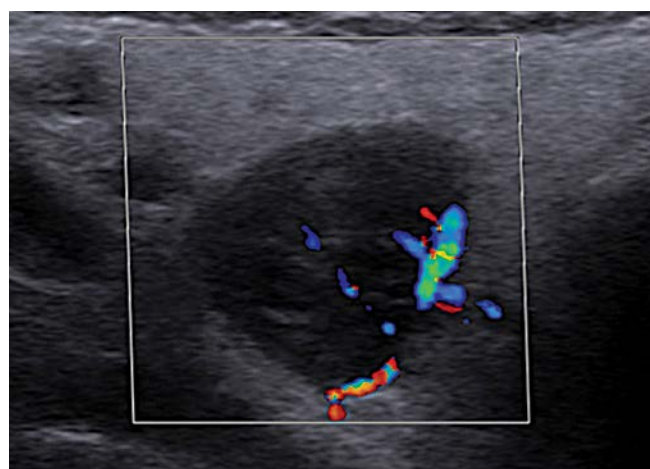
Color-coded duplex sonography of one tumor in the right parotid gland which is peripherally vascularized (2. case)
